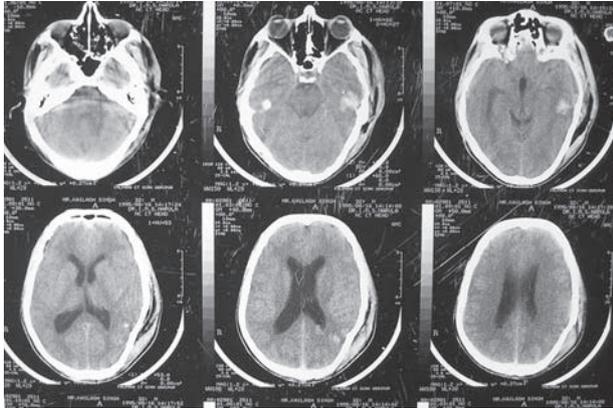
CT showing left temporal contusion
